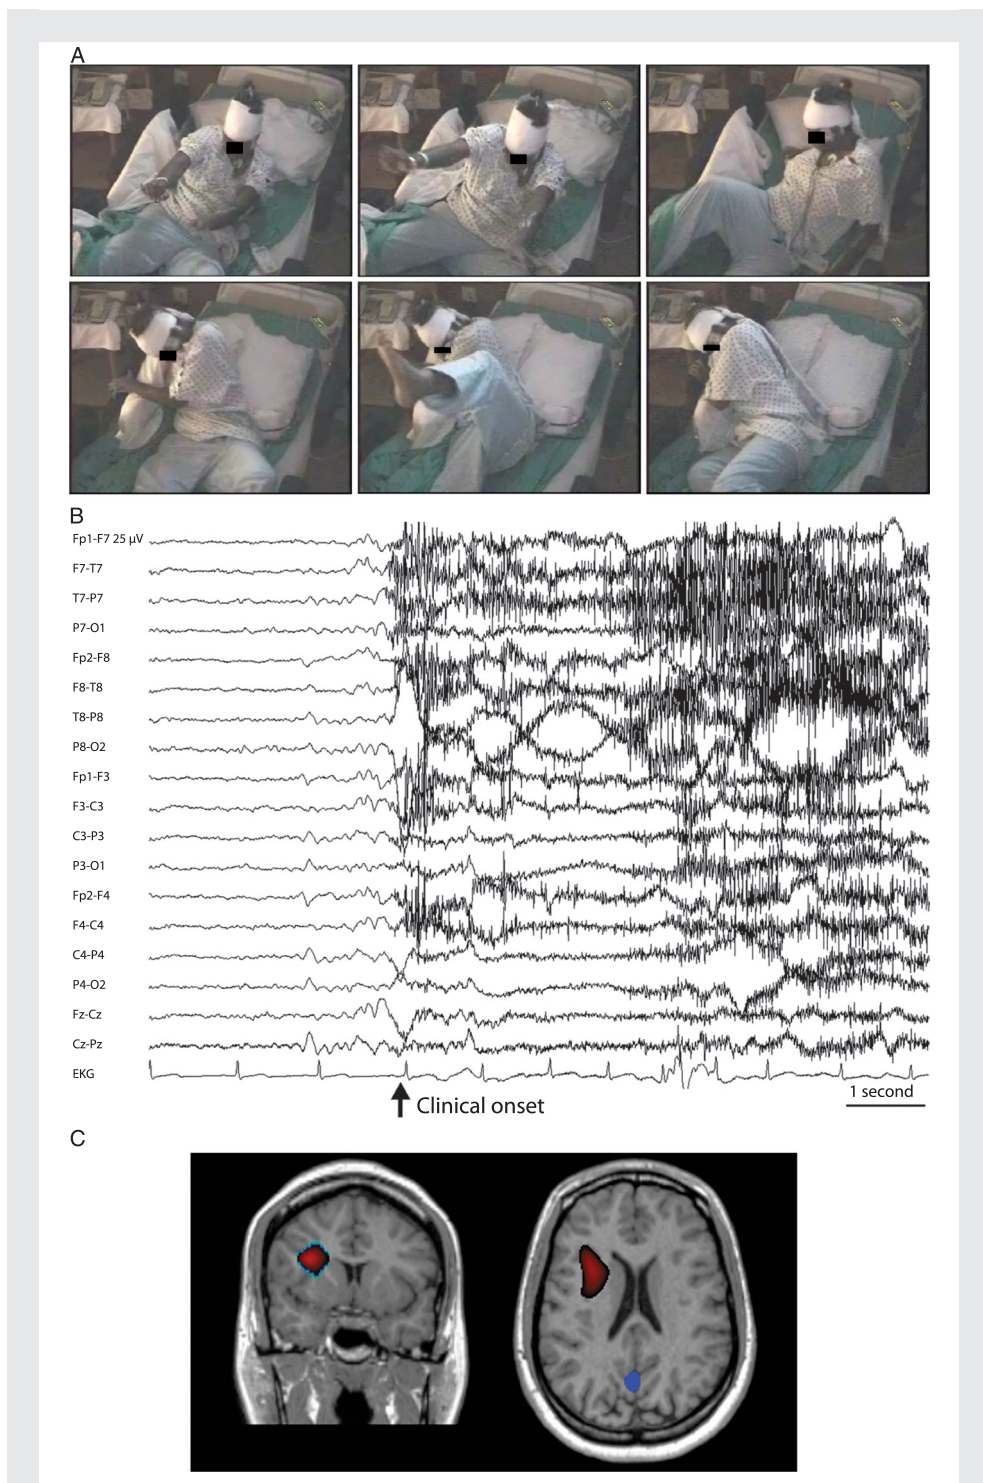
Components of a presurgical evaluation in a 26-year-old woman with pharmacoresistant nocturnal frontal lobe epilepsy. Hypermotor seizures are characterized by abrupt arousals associated with uncontrollable movements, including grasping, thrashing, and crawling (A) with preserved awareness lasting 10 to 20 seconds and occurring multiple times per night with a scalp EEG devoid of epileptiform activity and obscured by muscle and movement artifact (B). Ictal SPECT with flush time of 12 seconds reveals a dominant focus of hyperperfusion (red) in the right anterior insular and adjacent deep frontal region (C).
